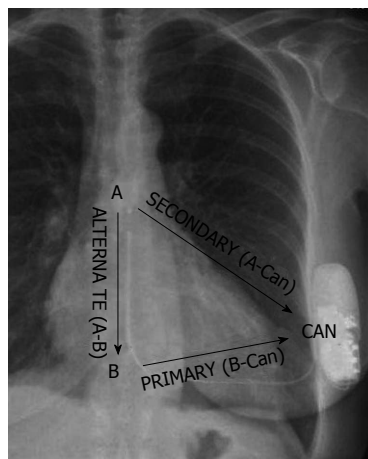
Chest X-ray of a patient with a subcutaneous implantable cardioverter-defibrillator system. The cardiac rhythm is detected by 1 of the 3 available vectors, formed between the 2 sensing electrodes and the pulse generator: B-Can, A-Can, and A-B. B-Can: Proximal-to-can; A-Can: Distal-to-can; A-B: Distal to proximal.
